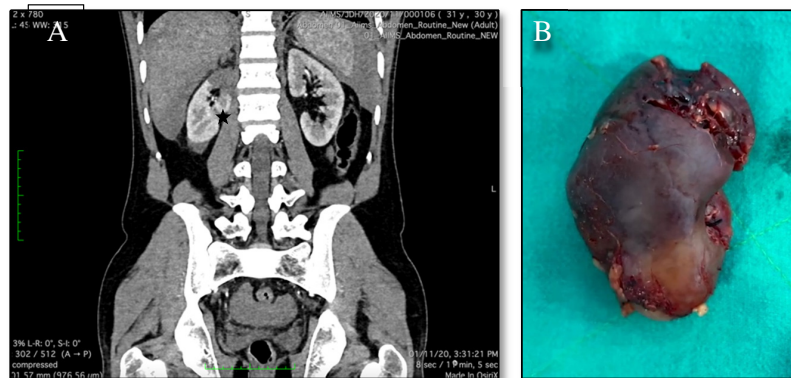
A- Axial cut Contrast-enhanced CT showing Grade 3 Renal laceration
